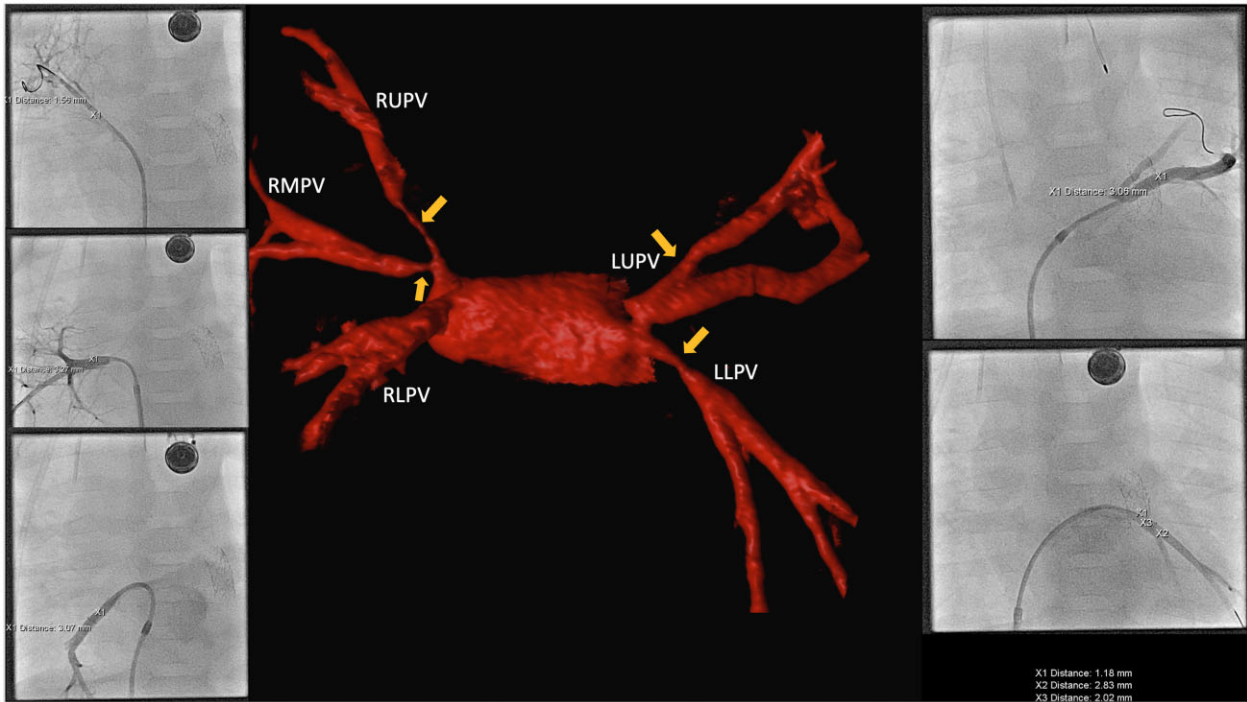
Computed tomography angiography reconstruction: the central image is a computed tomography angiography reconstruction showing stenotic pulmonary veins emptying into the left atrium. The orange arrows denote areas of stenosis. The image next to each pulmonary vein corresponds to an angiographic image of that vein taken during a subsequent cardiac catheterization. LLPV, left lower pulmonary vein; LUPV, left upper pulmonary vein; RLPV, right lower pulmonary vein; RMPV, right middle pulmonary vein; RUPV, right upper pulmonary vein.
